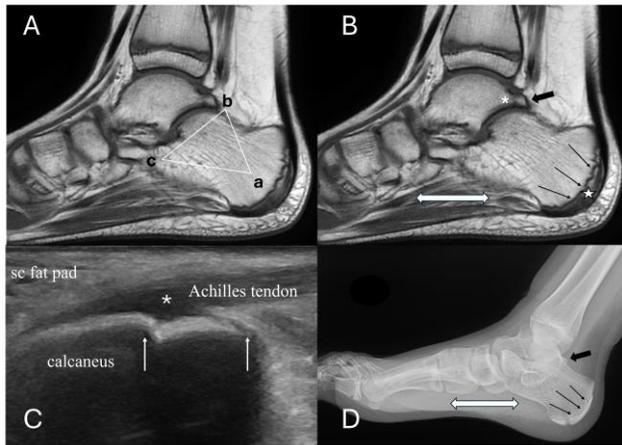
(Imaging of the right foot): Representation of three distinct diagnoses on MRI, reminiscent of the “Bermuda Triangle”:
